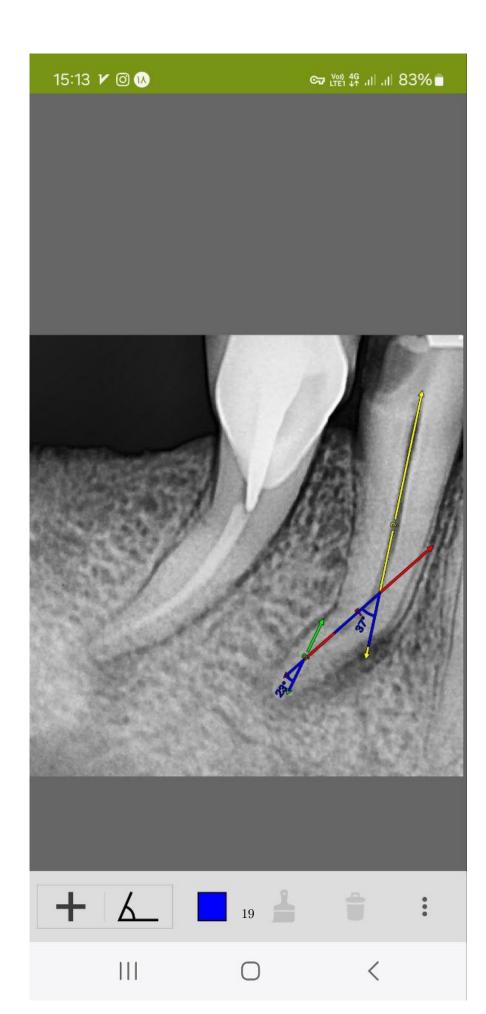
A) Initial view showing periapical pathology, B) Working length determination, C) Master cone fit, D) Obturation view, E) One-year follow-up demonstrating healing, F) Curvature angle calculation by Southard approach.
